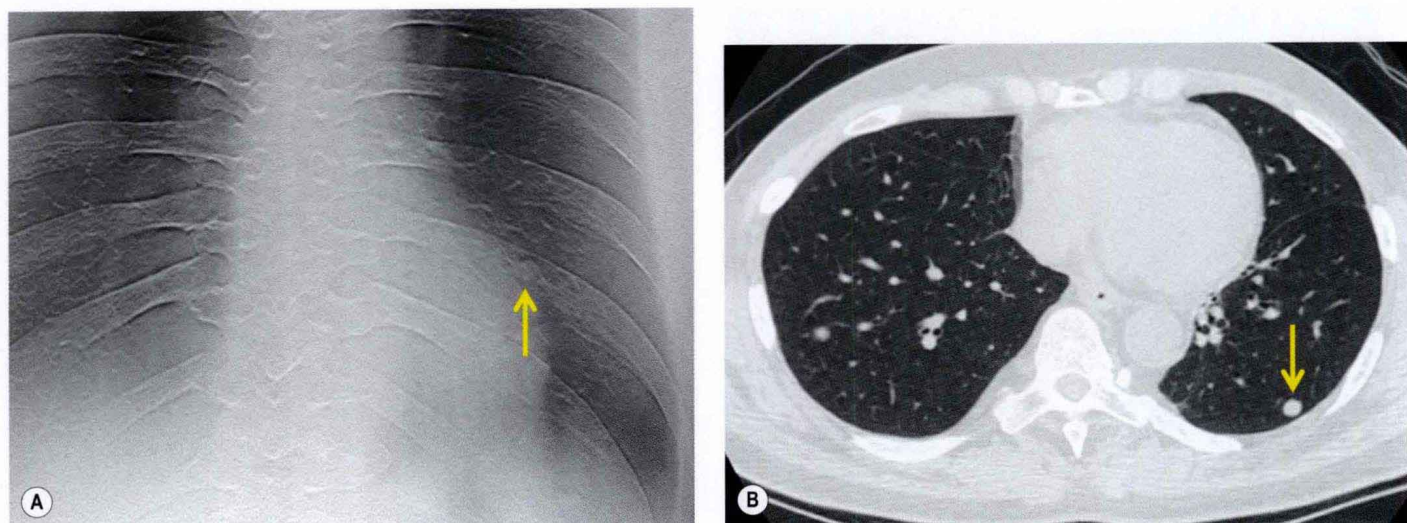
Digital tomosynthesis. A, Tomosynthesis image shows left lung nodule overlying a rib (arrow). B, Presence of subpleural nodule is confirmed by CT (arrow). (Courtesy of H Page McAdams, Durham, NC, USA.)
